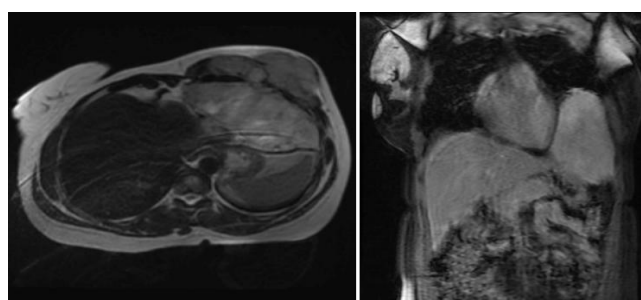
Thoracic magnetic resonance imaging (MRI) T1 sequence showing a tissue mass measuring 146 x 121 x 124 mm on the left anterior thoracic wall enveloping the anterior arches of the 6th, 7th and 8th left ribs, described as hypointense on T1 with heterogeneous enhancement after contrast injection
